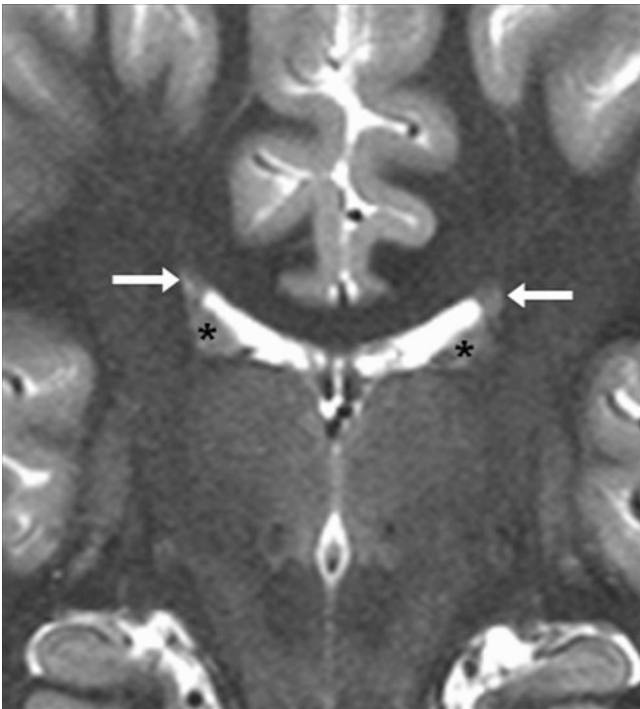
A 10 year old whose 3 T MRI showed asymmetric PEPs (*arrow*), the left being slightly more prominent than the right. Note the caudate heads (*) inferiorly
